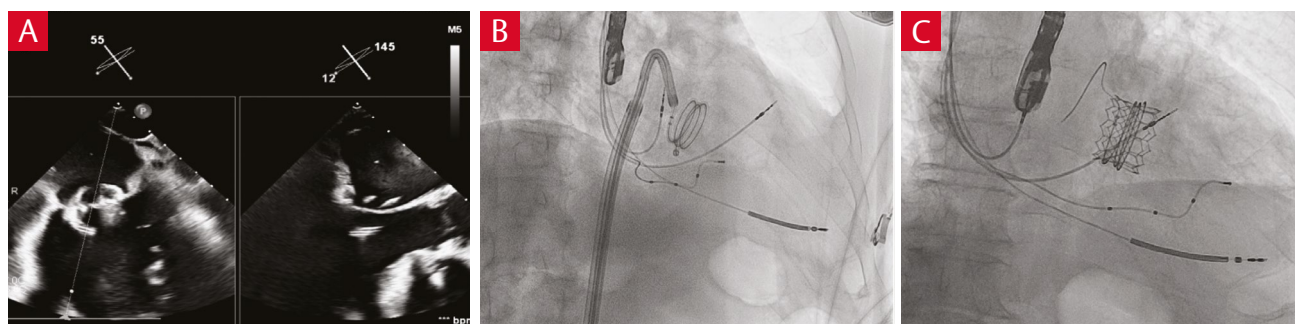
Echocardiography and cardiac angiography images showing successful encirclement (A/B) and valve deployment (C).
